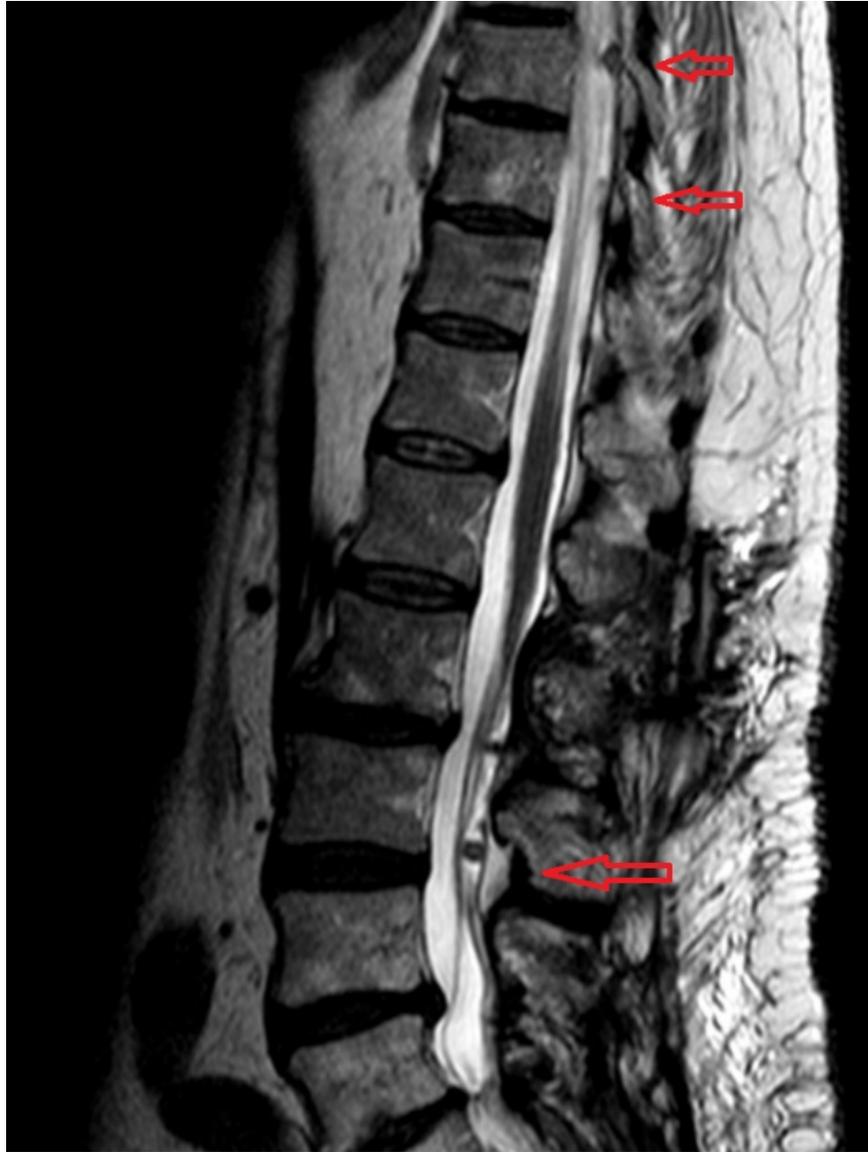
MRI after surgery showing leptomeningeal enhancement at the T9, T12 and L3 level.
